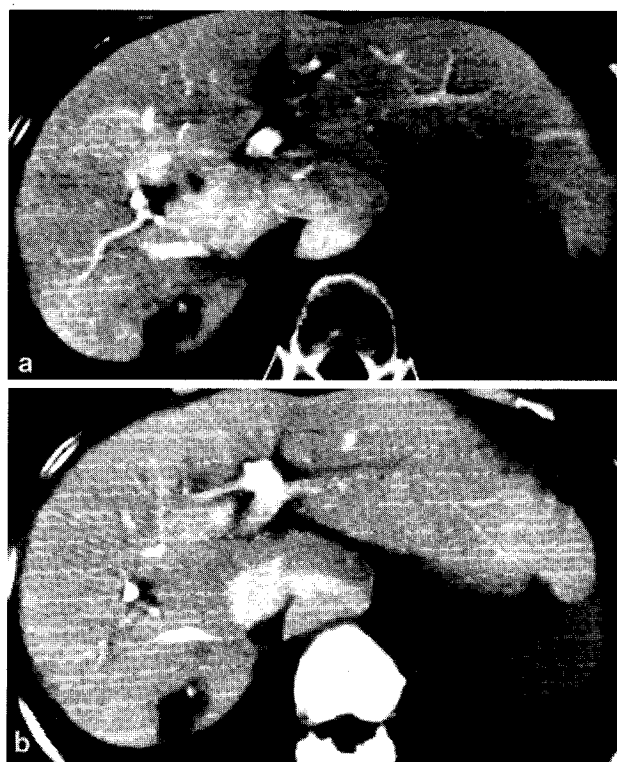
a) CTAP and b) CT-PTSP in a patient with hepatocellular carcinoma.
